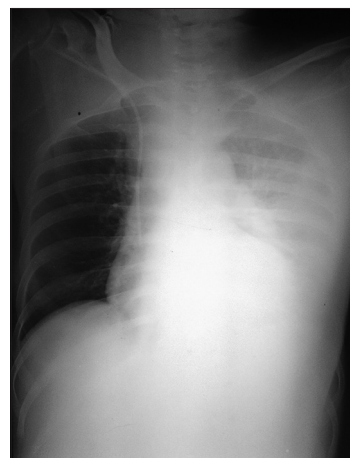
Chest X-ray on post-transplant day 5 showing a massive left pleural effusion
